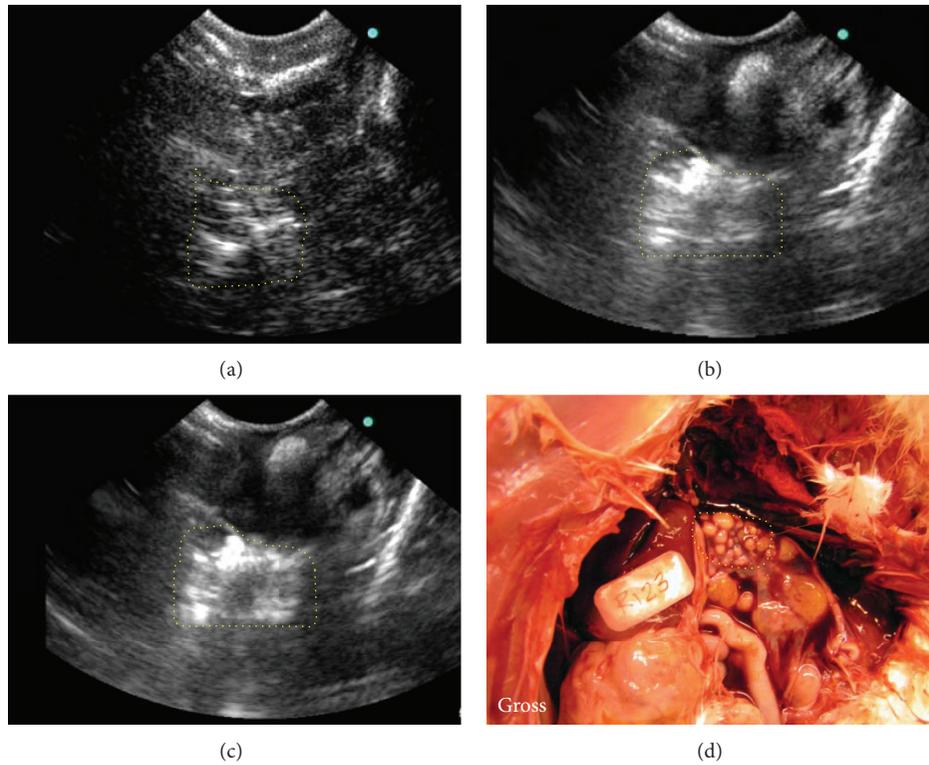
Detection of spontaneous ovarian tumors at early stage in hens by IL-16-targeted contrast enhanced ultrasound imaging. (a) Precontrast ovarian sonogram showing low intensity of ultrasound imaging. Presence of tumor-related solid mass in the ovary is inconclusive. (b)-(c) Corresponding contrast enhanced sonogram with enhanced visualization of ultrasound imaging at 5 min and 7 min after the injection of contrast agents, respectively, suggesting the presence of a small solid mass (yellow dotted lines) in the ovary. (d) Gross morphology shows the presence of a tissue mass (yellow dotted line) limited to a part of the ovary accompanied with a little ascites.
